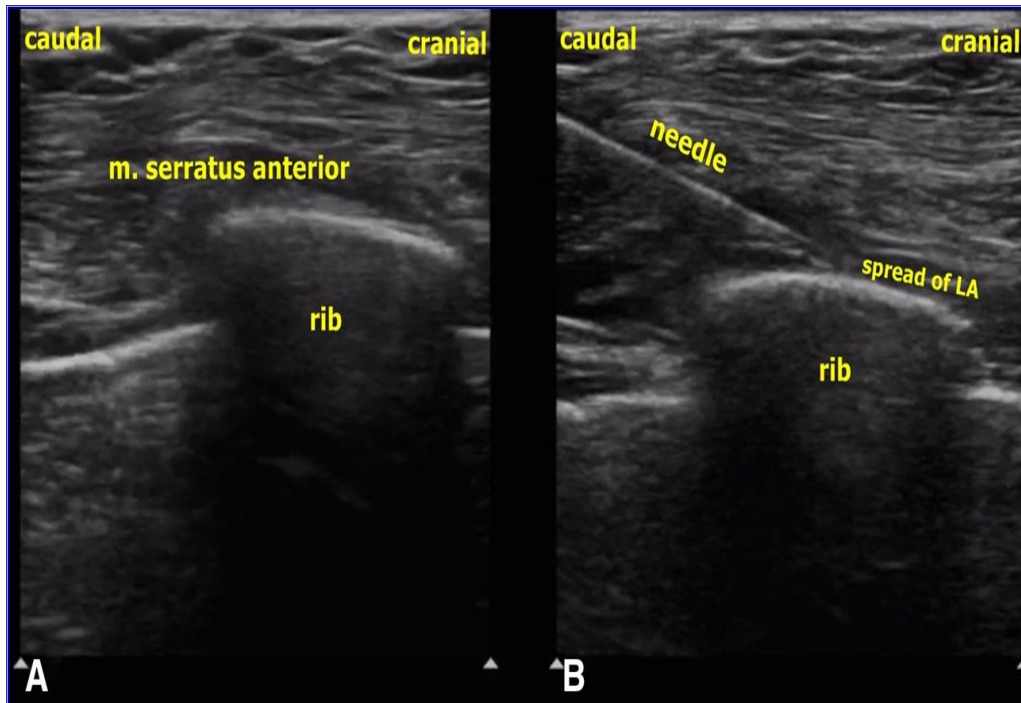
A) Sonographic anatomy of the SAPB. The serratus anterior muscle and the rib are seen. B) Needle direction, craniocaudal spread of local anesthetic during SAPB [18].
